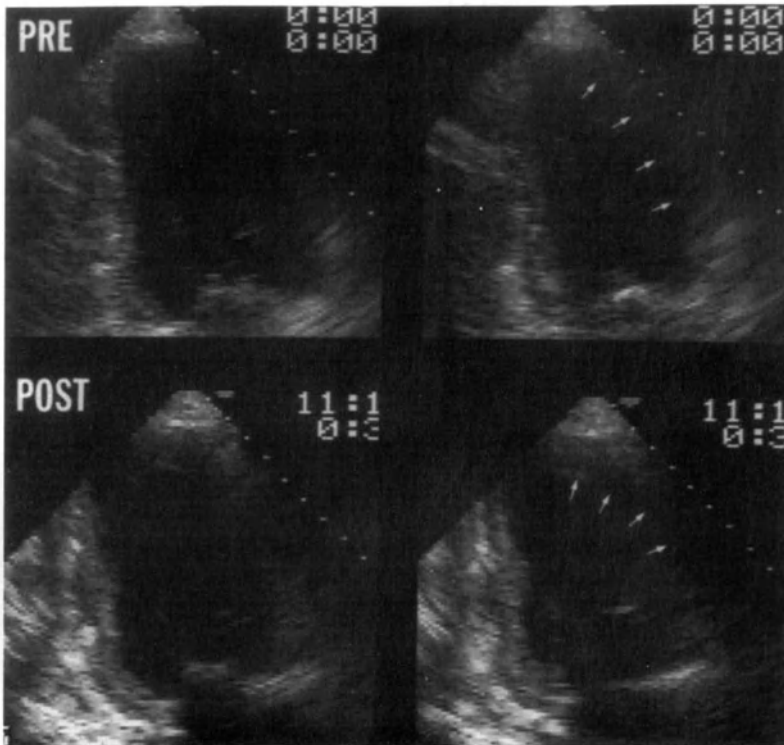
Stop-frame images of apical 2-chamber views in a patient with apical anterior wall ischemia (arrows). The aortic valve is not visualized – hence the walls are anterior and inferior, rather than anteroseptal and posterior (compare with Figure 2.3).
